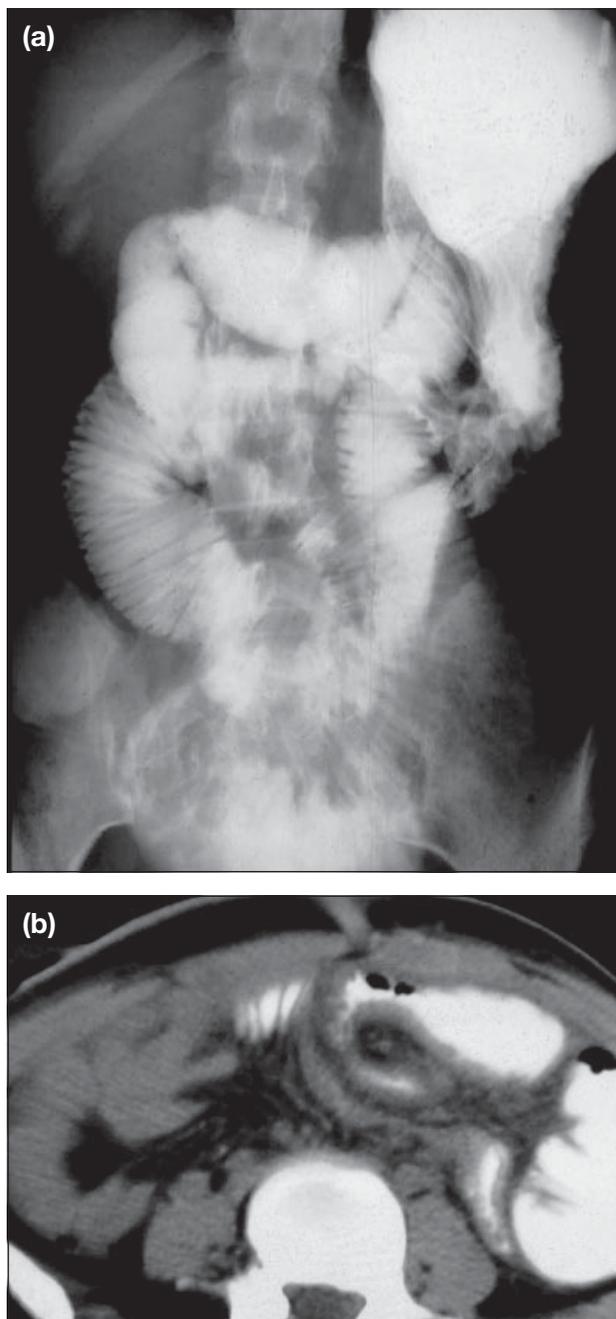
Small bowel obstruction in the proximal ileum demonstrated by (a) water soluble contrast study, with (b) computed tomography scan demonstrating anterior adhesions as the underlying cause.
